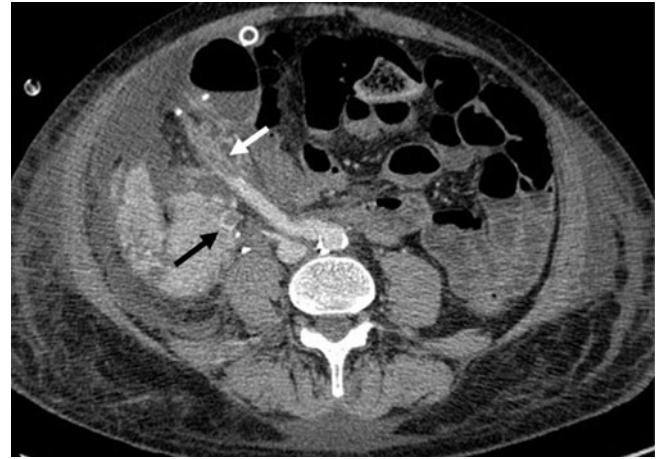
Axial CT image in a patient following SPK depicting a non-occlusive thrombus within the donor portal vein (*black arrow*) and donor superior splenic artery (*white arrow*). Also note generalized anasarca suggesting low-flow states and possibly predisposing to thromboses.
